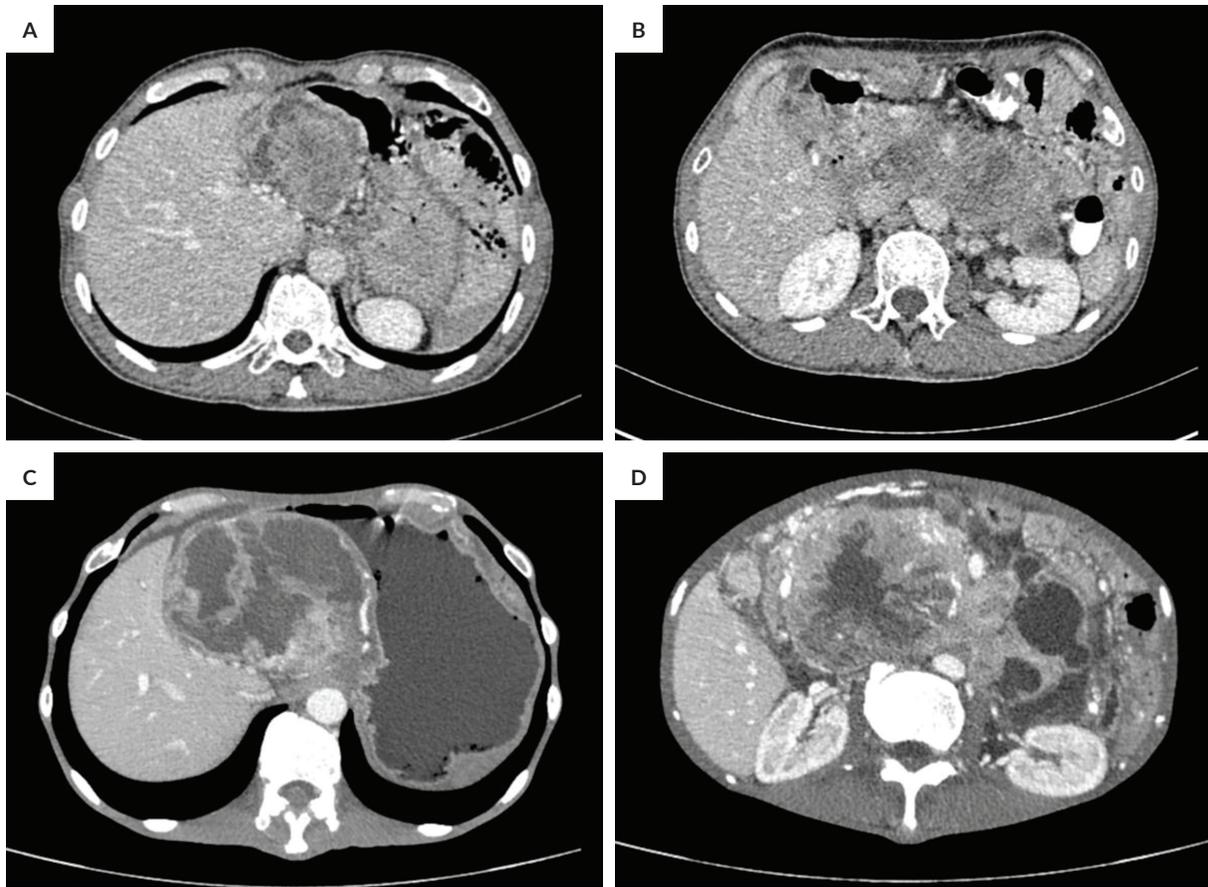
Contrast-enhanced abdominal CT images at the level of the gastrohepatic region and surgical bed showing: (A,B) Enlarged solid-cystic masses, consistent with tumor recurrence six months after surgery. (C,D) Increase in size of nodal-peritoneal metastases with an overall response +50.3% based on RECIST 1.1, after five cycles of doxorubicin chemotherapy, consistent with disease progression.
